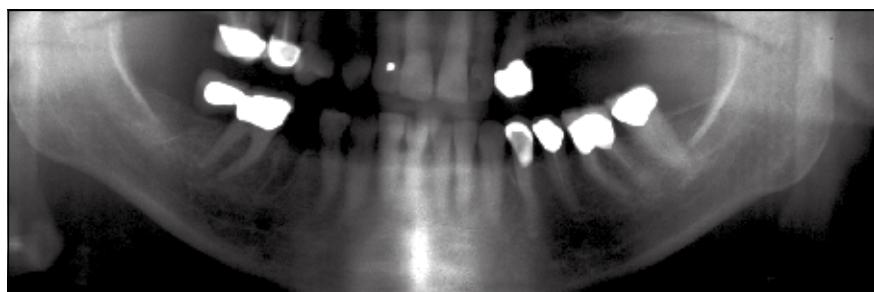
2007 panoramic radiograph taken shortly after extraction of the right mandibular second bicuspid. Note the trabecular pattern remains largely unaltered.
